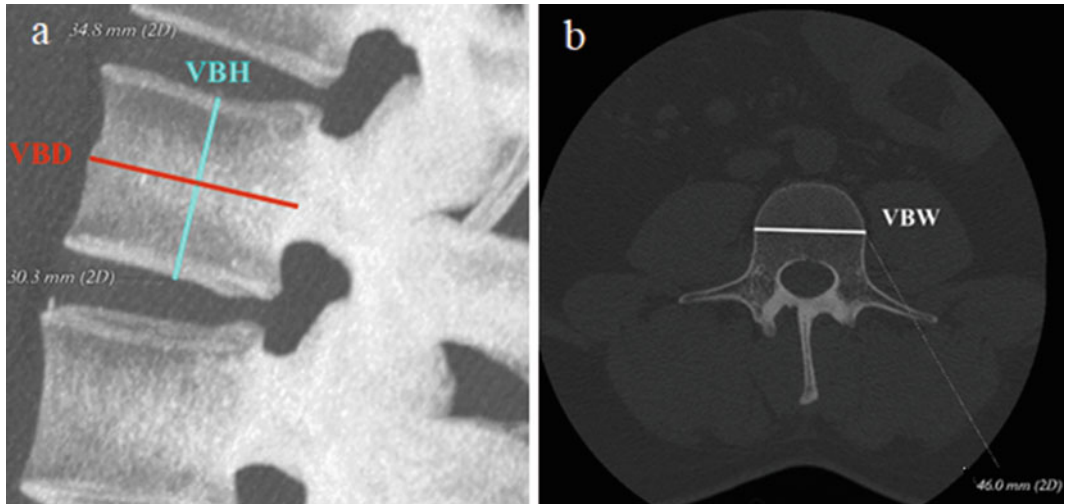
Sagittal sections of CT scans: (a) demonstration of the measurement of vertebral body height (VBH) and vertebral body depth (VBD) and (b) vertebral body width (VBW)
